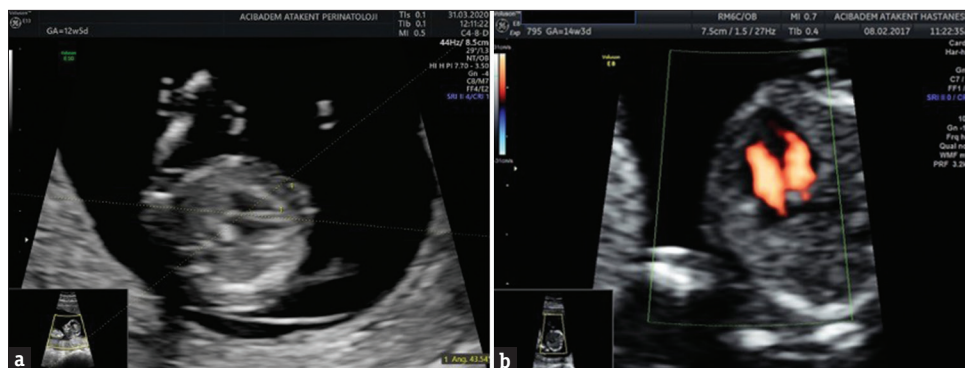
(a) Cardiac axis, 4-chamber view, (b) Two equal size and filled atria and ventricles were visualized by HD-flow Doppler exam.
